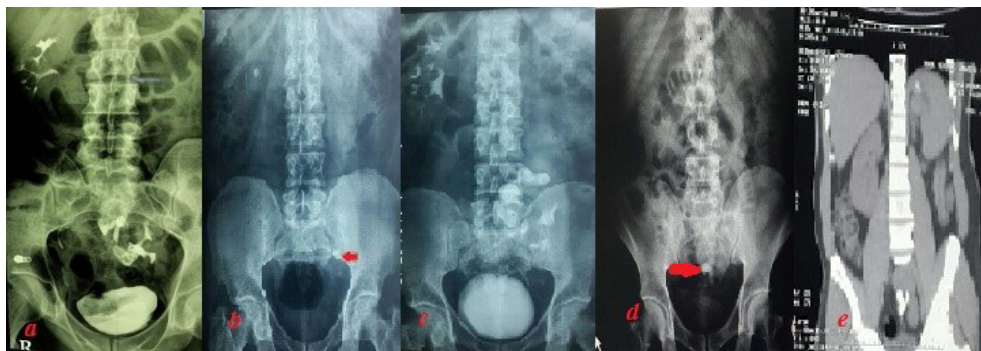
Intravenous pyelography (IVP) image of one of the patients shows multiple renal stones in left kidney (a). KUB and IVP show single stone in second patient (b, c) and KUB and coronal section of CT scan in last patient show three stones in left kidney (d, e).
